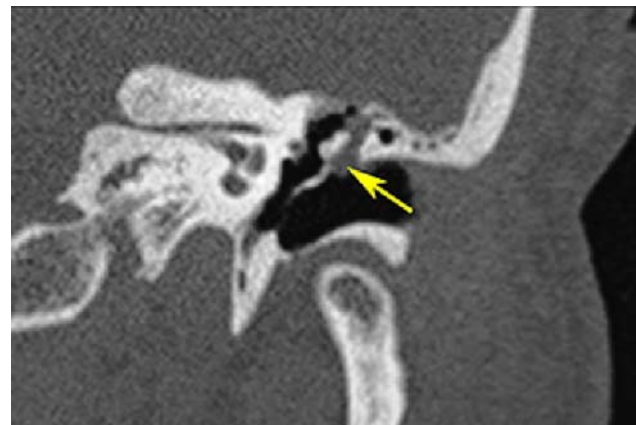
Cone beam computed tomography (CT) of temporal bone (arrow shows soft tissue of the attic cholesteatoma).
